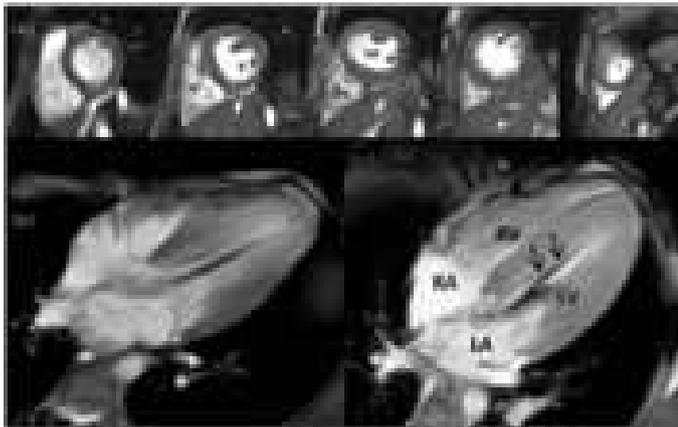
MRI images in (a) short axis view during diastole from base towards apex demonstrating focal asymmetric hypertrophy of the inferior LV septal myocardium (arrow). (b) 4 chamber view in systole shows mid-cavitary jet (black arrows) seen as black linear area in the left ventricle (LV). Right atrium – RA , Right ventricle – RV , Left atrium – LA , Left ventricle – LV.
